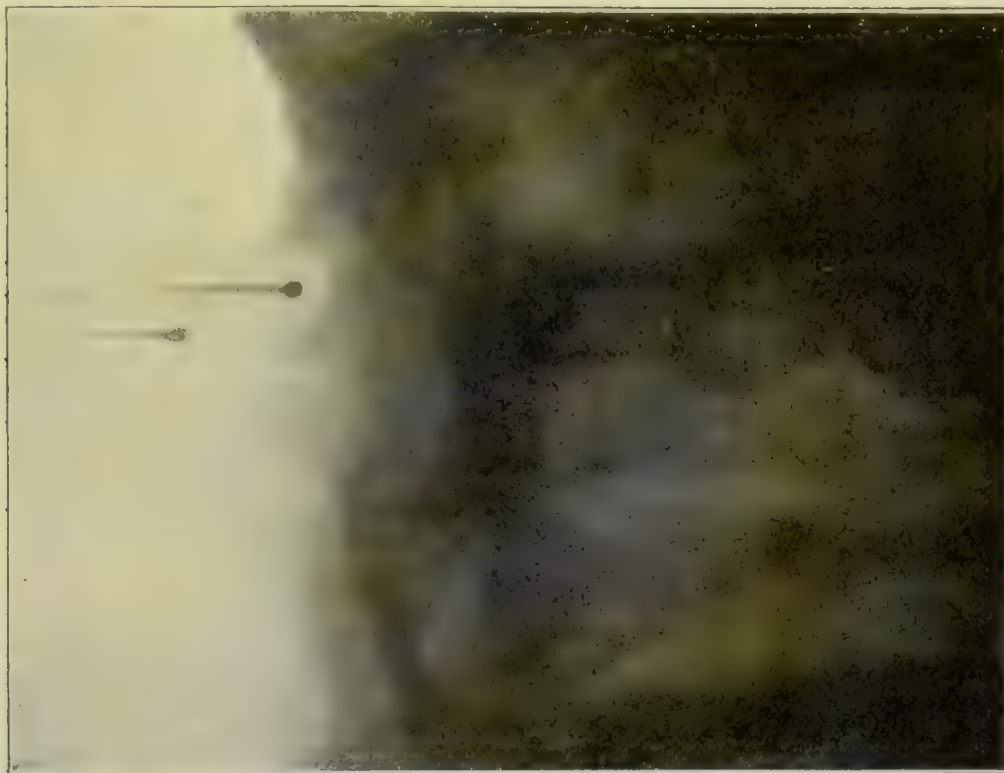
Radiograph made with tube below horizontal plane of indicators.
